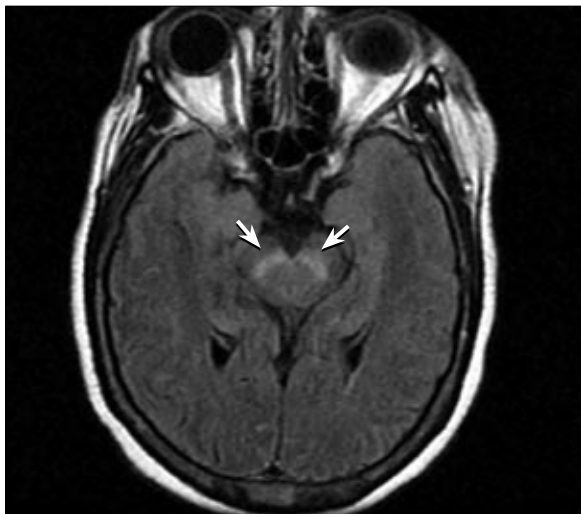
Axial FLAIR MR image shows hyperintense signal in the location of the previously visualized restricted diffusion on day 6.
